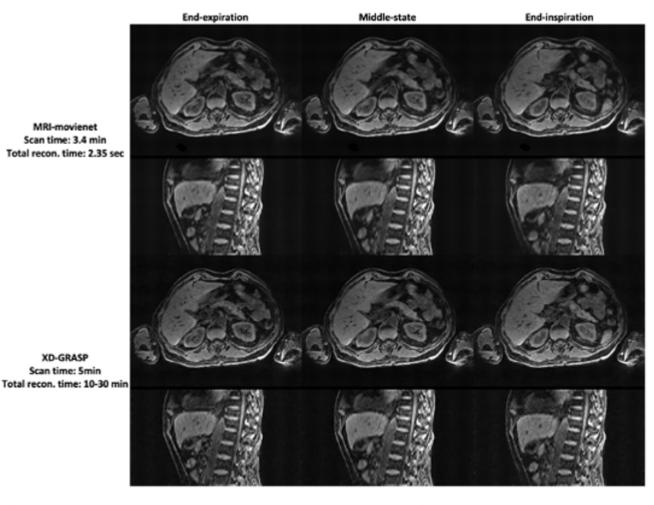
4D MRI reconstruction for one patient using MRI-movienet and XD-GRASP. Three respiratory motion states (end-expiration, middle-state, and end-inspiration) for axial and sagittal orientations are shown for each reconstruction method.
